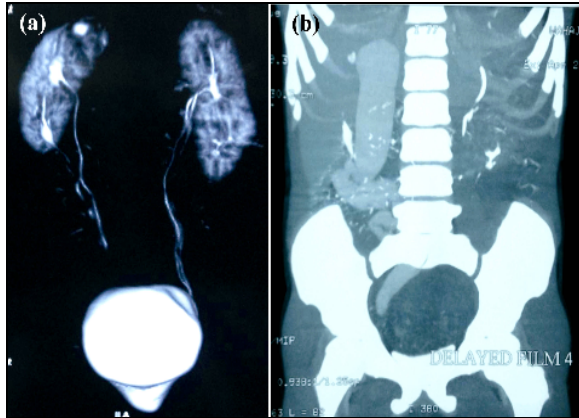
(a):– CT Urogram. Early film showed bilateral duplex kidneys and right side triplex ureter not opacified. (b): CT-urogram (Delayed Film) outlined grossly dilated ureter of triplex right upper moiety.
